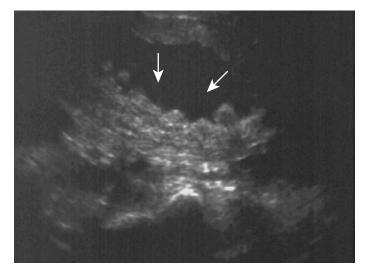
Ultrasound image of the urinary bladder showing thickened bladder wall and trabeculations of the mucosa (arrows) in a patient with neurogenic bladder.
